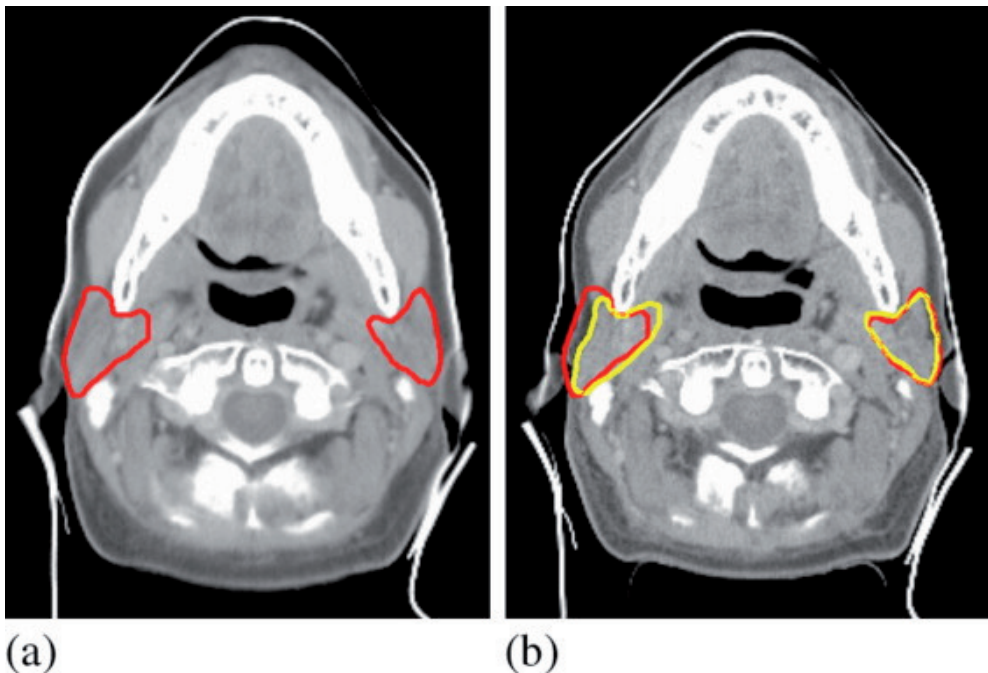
Patient with unilateral irradiation (right neck). (a) Planning computed tomography scan. Red contours indicate parotid glands. (b) Computed tomography scan after external beam radiotherapy. Yellow contours indicate parotid glands after treatment; red contours, parotid glands before treatment.
